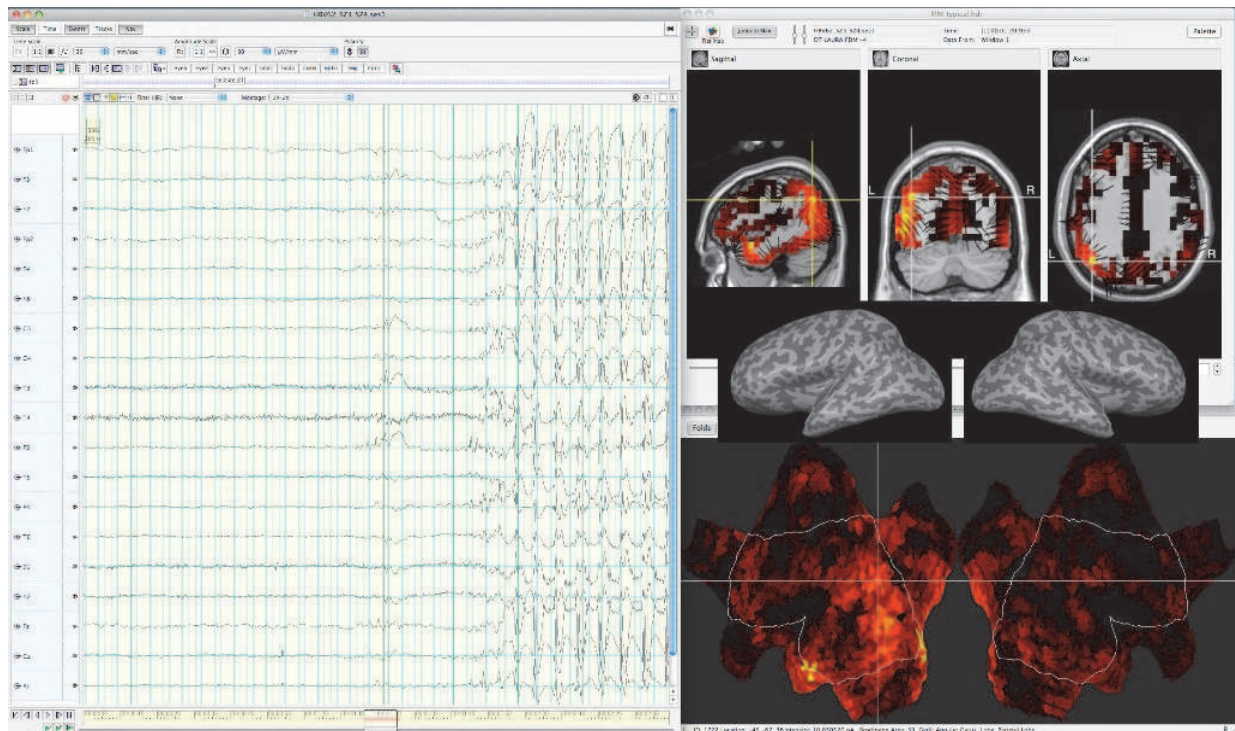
This figure demonstrates the seizure onset of one subject. The standard EEG (left side) shows that the seizure is heralded by poorly localized discharges over left posterior quadrant. Source analysis of one dEEG-recorded seizure suggests that the onset is localized to left parietal cortex (top right). The “flatmap” of flattened cortical surface of standard MRI used in source analysis denotes regions of maximal intensity with crosshairs (bottom right). See also Fig. 3.
